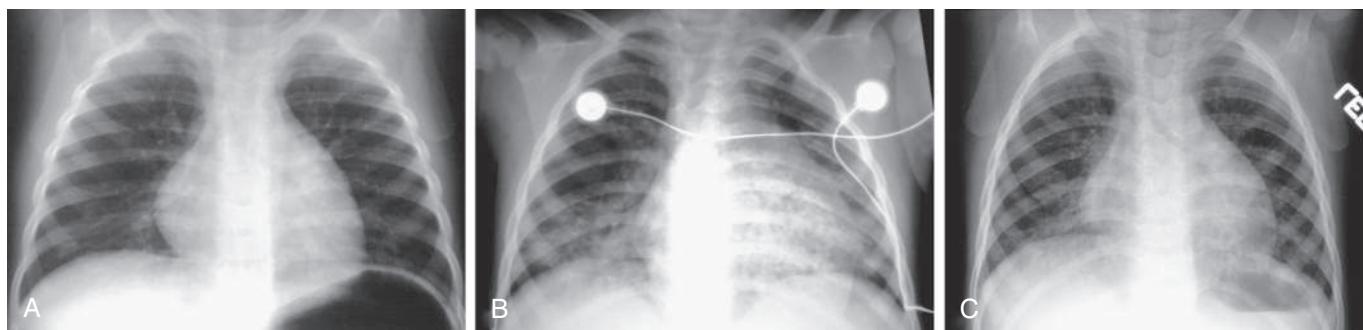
Chest radiographs of a 17-mo-old toddler with hydrocarbon ingestion. A, Three hours after ingestion, the lungs are clear. B, At 24 hours, there are bibasilar coalescing nodular opacities. C, Three days later there is much clearing. (From Slovis T, ed. Caffey's Pediatric Diagnostic Imaging, 11th ed. Philadelphia: Mosby; 2008:1287.)
